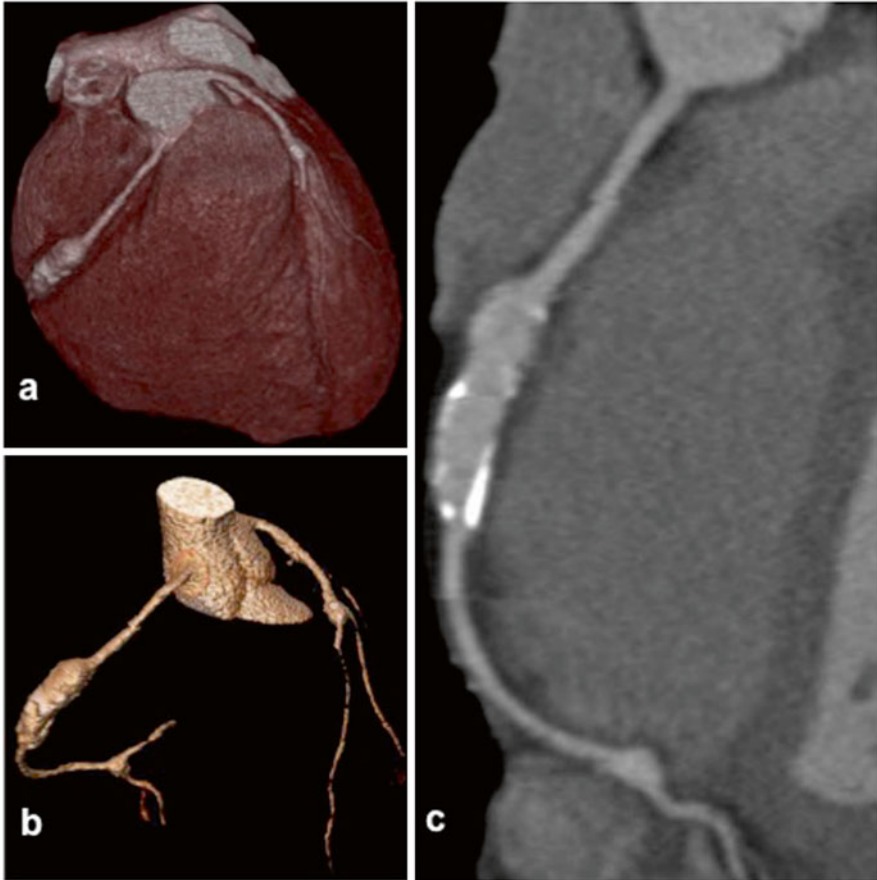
Coronary CTA in a patient with Kawasaki's disease: volume-rendering reconstructions (a and b) show a fusiform aneurism on middle tract of the right coronary artery. Curved multiplanar reconstruction (c) demonstrates the partially calcified walls of the aneurism
